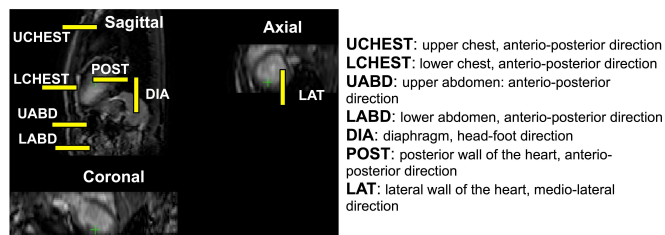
Positioning of virtual navigators on a dynamic MRI scan.
